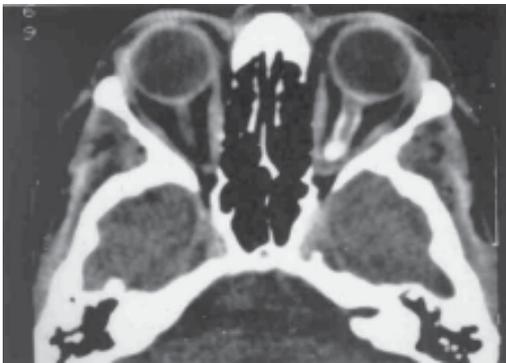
Axial non-contrast CT scan in a patient with a left optic nerve sheath meningioma demonstrates a hyperintense left optic nerve sheath with central lucency corresponding to the nerve; i.e., the “tram-track” sign.
